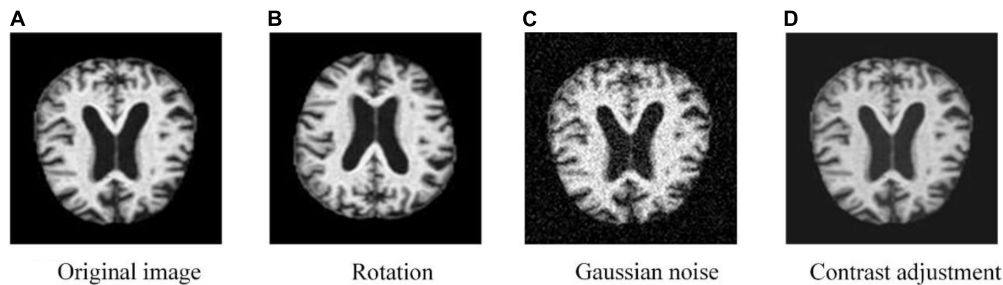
MRI image processed by augmentation methods.
